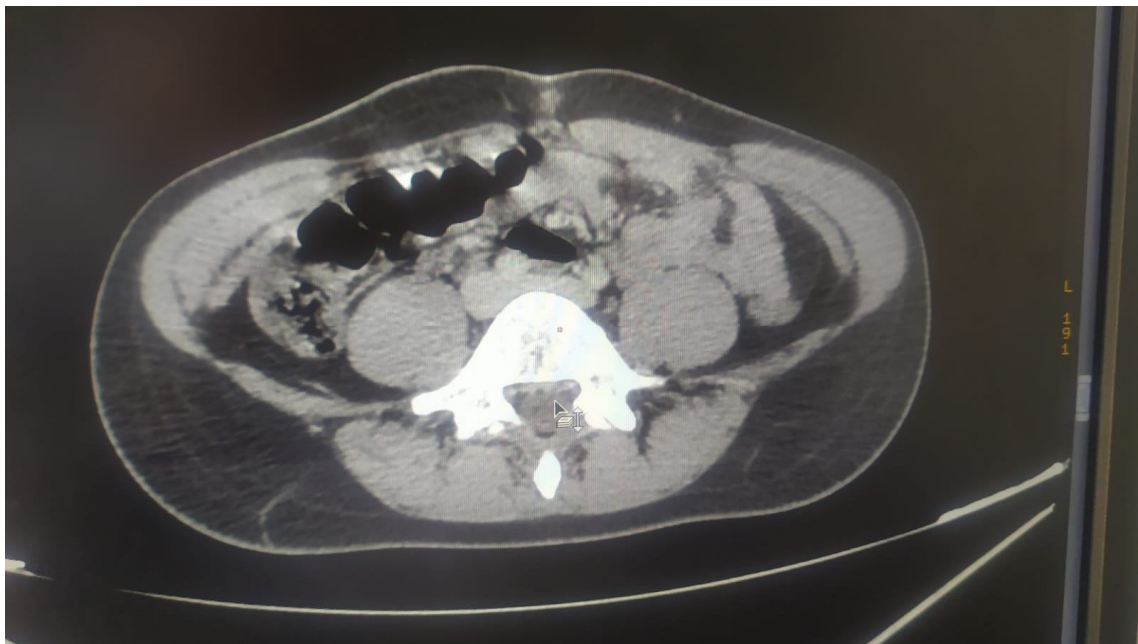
abdominal CT image showing appendix in latero-caecal position with ascending
